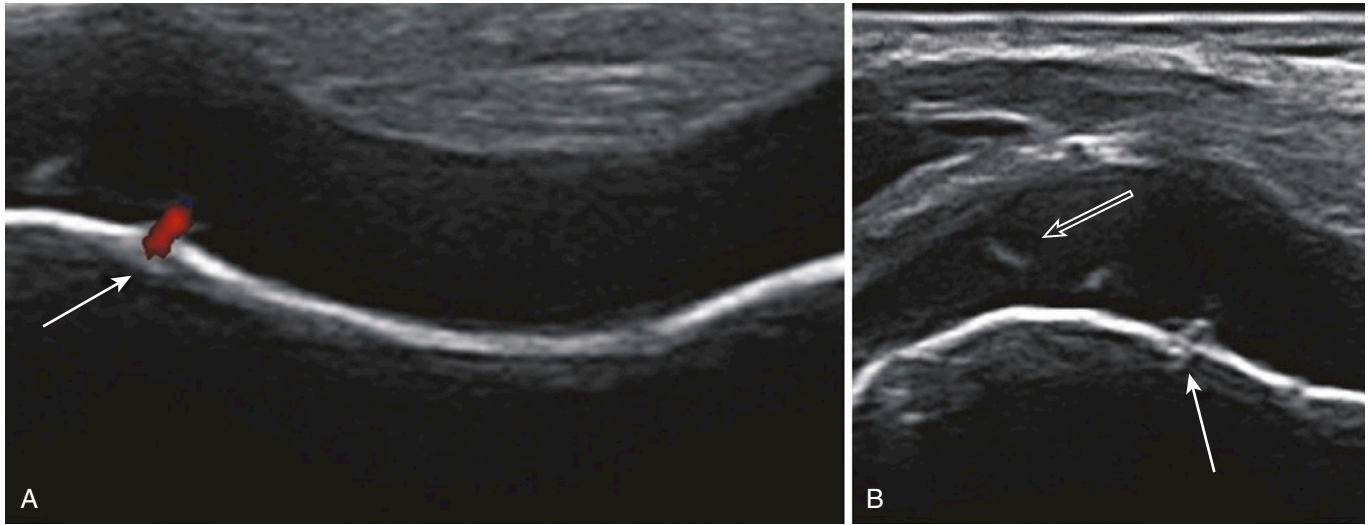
HYALINE CARTILAGE OF THE FEMORAL CONDYLE. Ultrasound shows the hyaline cartilage of the femoral condyle in a 6-year-old girl. A, A physiologic vessel (arrow) can be seen on the subchondral bone-hyaline cartilage interface. B, Irregularity of the subchondral bone contour (arrow) and focal hyperechogenic areas within the cartilage (open arrow) are observable.
